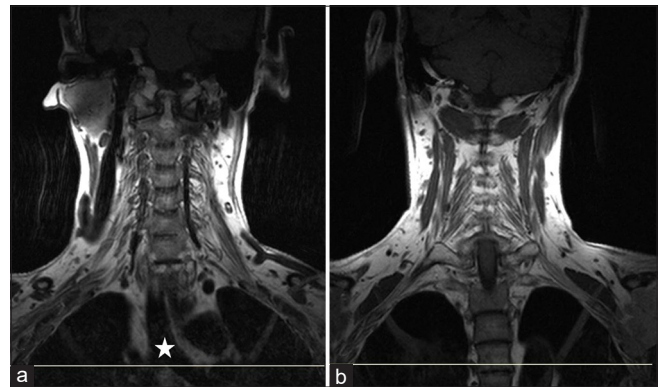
T1-weighted coronal images. (a) Reference line across carina (star). (b) Reference line extending up to the dorsal vertebra
